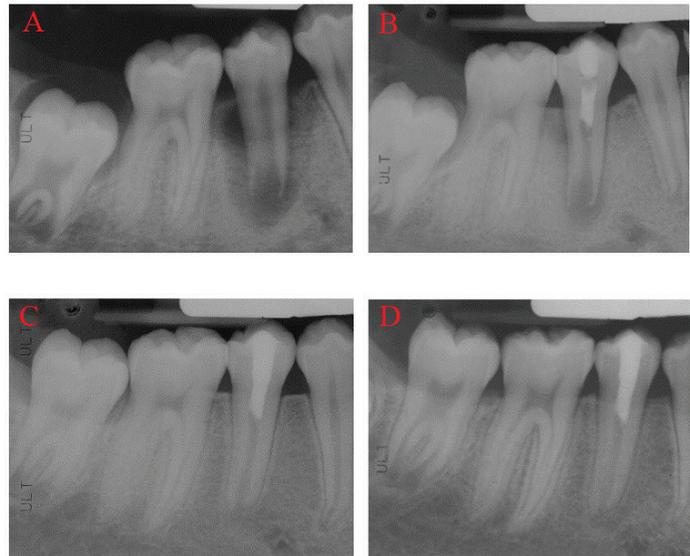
(A). Preoperative radiograph. The second premolar has an open apex with a large periradicular radiolucency. (B) Radiograph confirming the placement of MTA approximately 3 mm below the CEJ. The MTA was carefully placed over the blood clot, followed by a wet cotton pellet and Cavit. (C) Twelve-month radiograph showing continued root development. (D) Eighteen-month radiograph showing continued root development.
